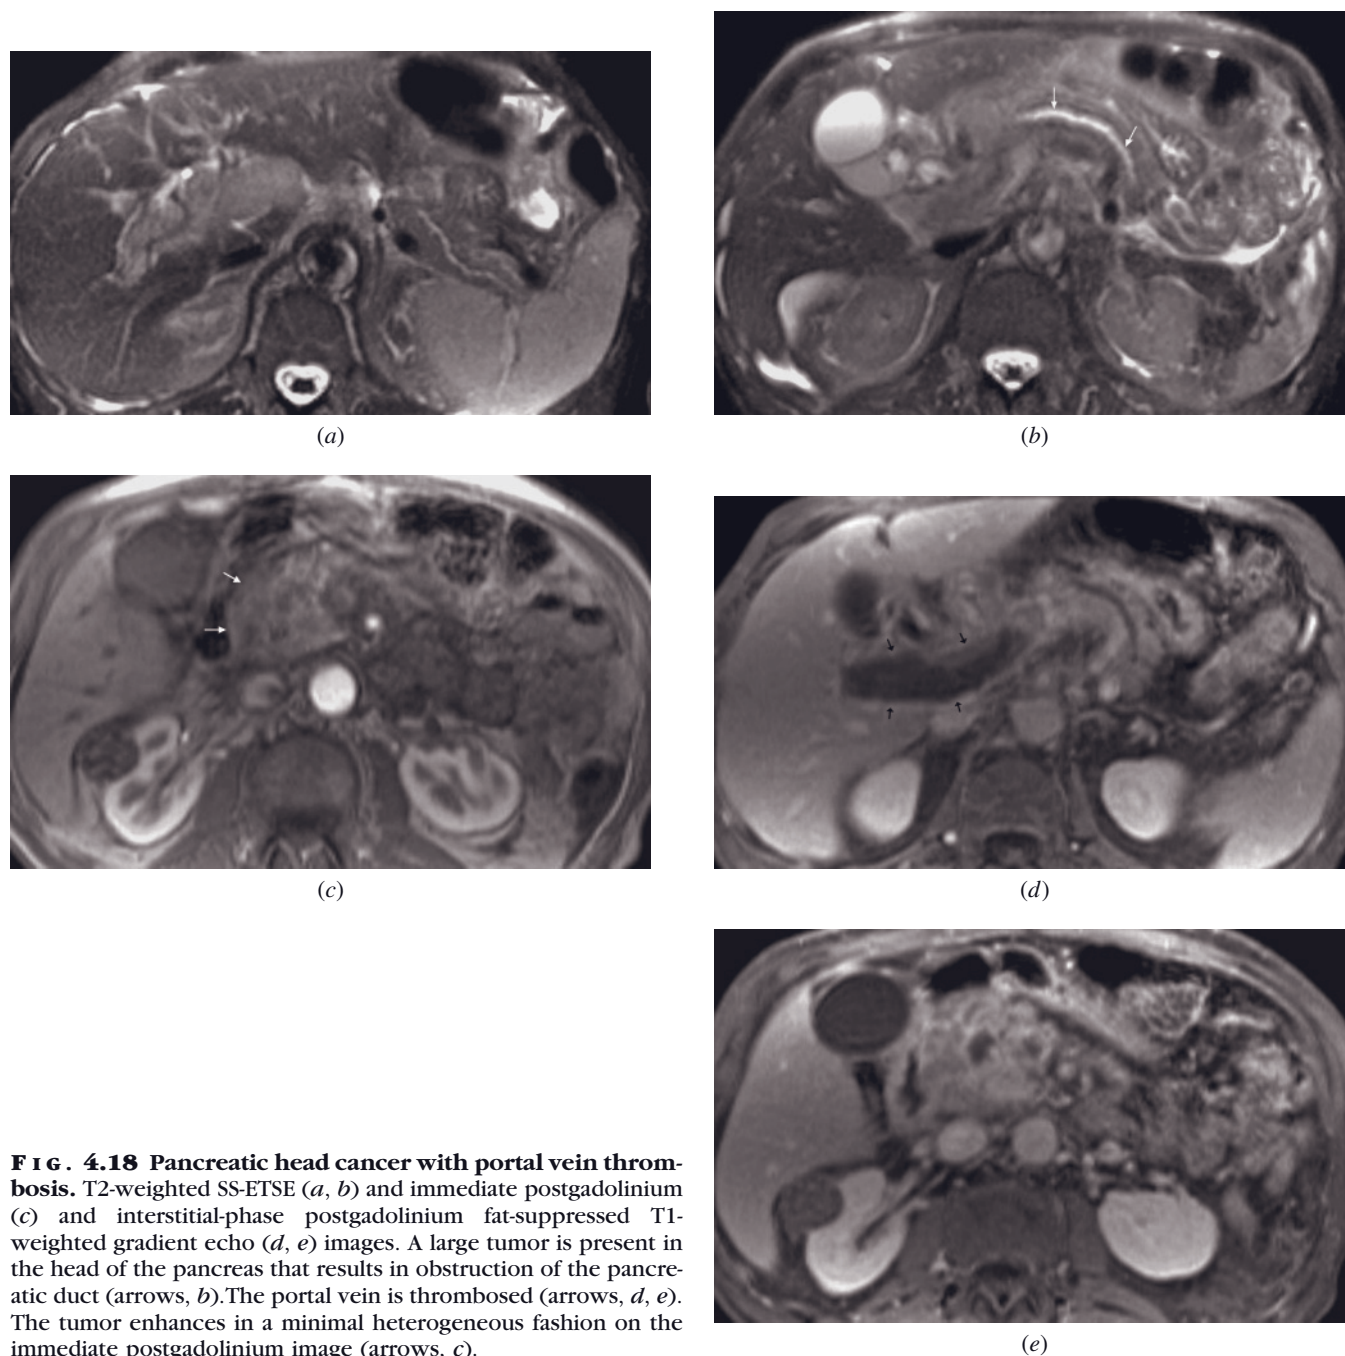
Pancreatic head cancer with portal vein thrombosis. T2-weighted SS-ETSE (*a, b*) and immediate postgadolinium (*c*) and interstitial-phase postgadolinium fat-suppressed T1-weighted gradient echo (*d, e*) images. A large tumor is present in the head of the pancreas that results in obstruction of the pancreatic duct (arrows, *b*). The portal vein is thrombosed (arrows, *d, e*). The tumor enhances in a minimal heterogeneous fashion on the immediate postgadolinium image (arrows, *c*).
